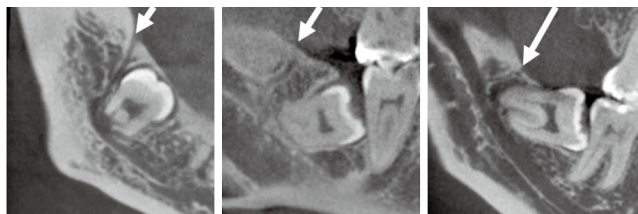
A typical image of the posterior canal on cone-beam computed tomography. The retromolar canal is the branch arising from the main canal, opening at the retromolar foramen (white arrows).
